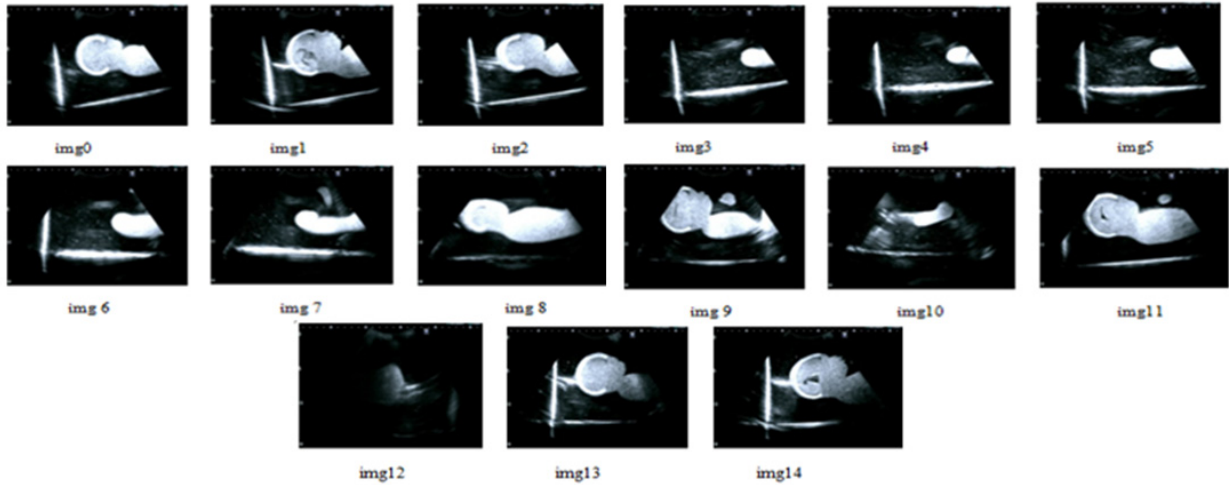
2D ultrasound images taken by using ultrasound machine
